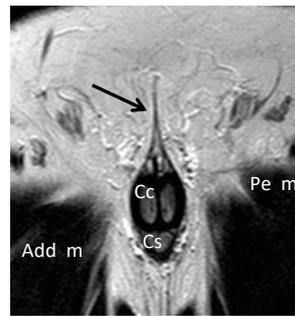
Coronal T 2-w TSE MR image taken at the level of the anterior abdominal wall with arrow pointing at the fundiform ligament: Add m = adductor muscles; Pe = pectineus muscle; ; Cc = corpus cavernosum; Cs = corpus spongiosum
